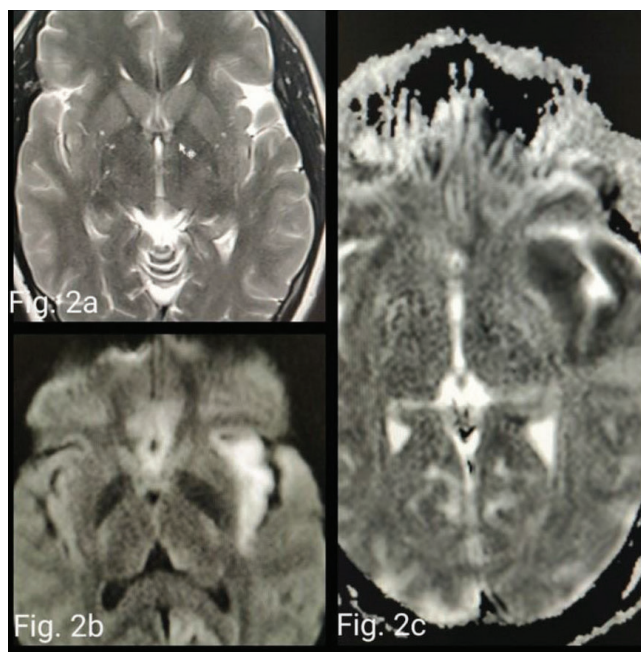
Axial T2W (a) image shows normal signal intensity in bilateral insular regions. DWI (b) and corresponding ADC (c) images show diffusion restriction in the left insula.
